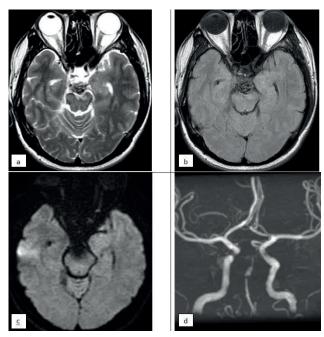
Cerebral MRI on the next day due to an appearance of nausea and vomiting revealed edema in bilateral pons (*a*, *b*). There were no signs of infarction on DWI (c). Thrombosis formed in the false lumen of dissecting aneurysm (d).
